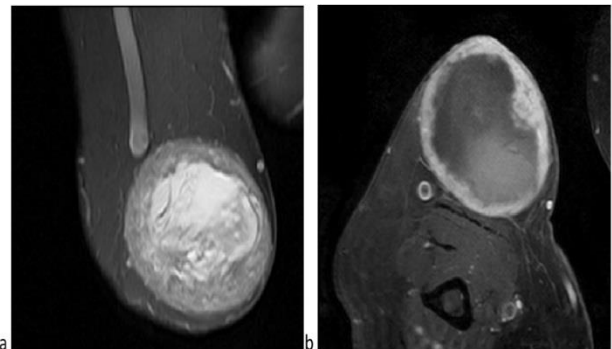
a) MRI showing cystic swelling; b) Contrast enhanced MRI showing thick peripheral enhancement
